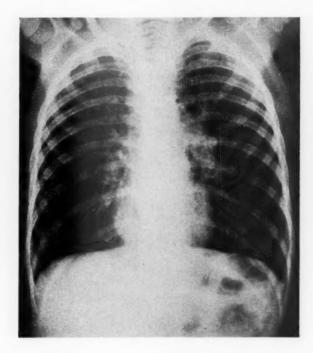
Case 3.—Roentgenogram taken at the time of the first admission. It shows the severe emphysema associated with the obstruction of the tracheobronchial tree by viscid mucus.
